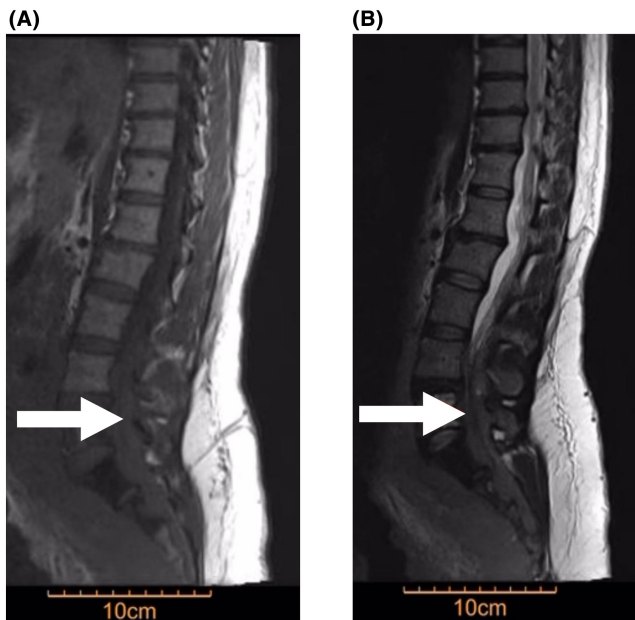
Sagittal T1-weighted (A) and T2-weighted (B) MRI demonstrate a 3 × 10 cm epidural mass lesion at L4 level to coccyx with low T1 marrow signal intensity in L5, S1, and S2, suggesting vertebral body involvement. White arrows point to the location of the mass.
